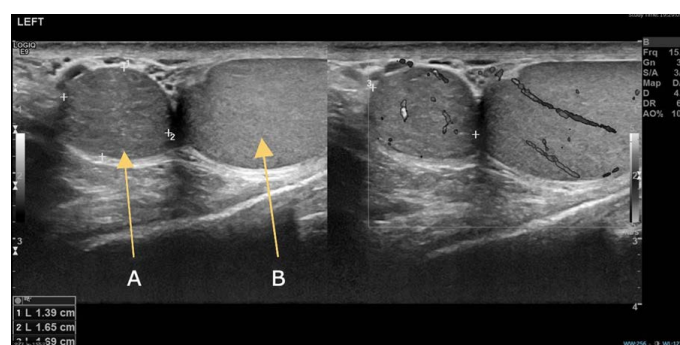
Ultrasound Doppler of the Scrotum.
